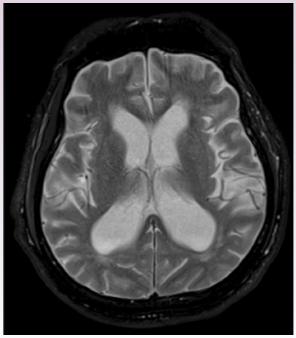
An axial (horizontal) computer tomograph (CT) and magnetic resonance image (MRI) of the same elderly patient with age-related cognitive decline. Note the enlarged ventricles and atrophy of the cortex (larger than normal sulci) in the brain.
